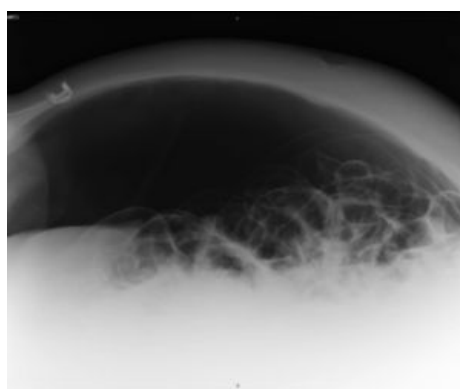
Tangential abdominal X-ray in the supine position showing a massive pneumoperitoneum.
